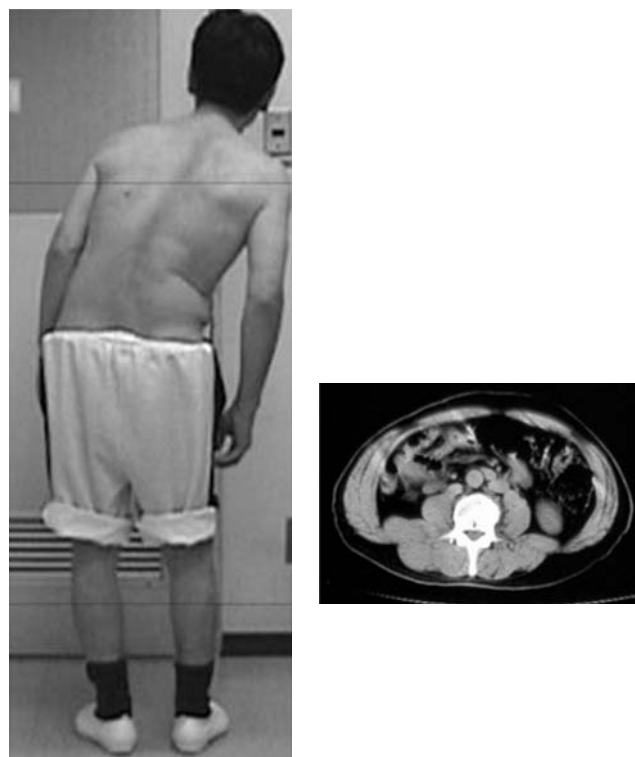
Subchronic type of lateral flexion similar to Pisa syndrome. Sixty-year-old patient with PD and illness duration of seven years. Lateral flexion to the right and forward developed 1 year ago. His medication was 300 mg of levodopa/DL, 150 mg of amantadine and 1.5 mg of pramipexole. A computed tomographic image shows a larger volume of the left paraspinal muscle than that of the right paraspinal muscle, which was contralateral to the lateral flexion
